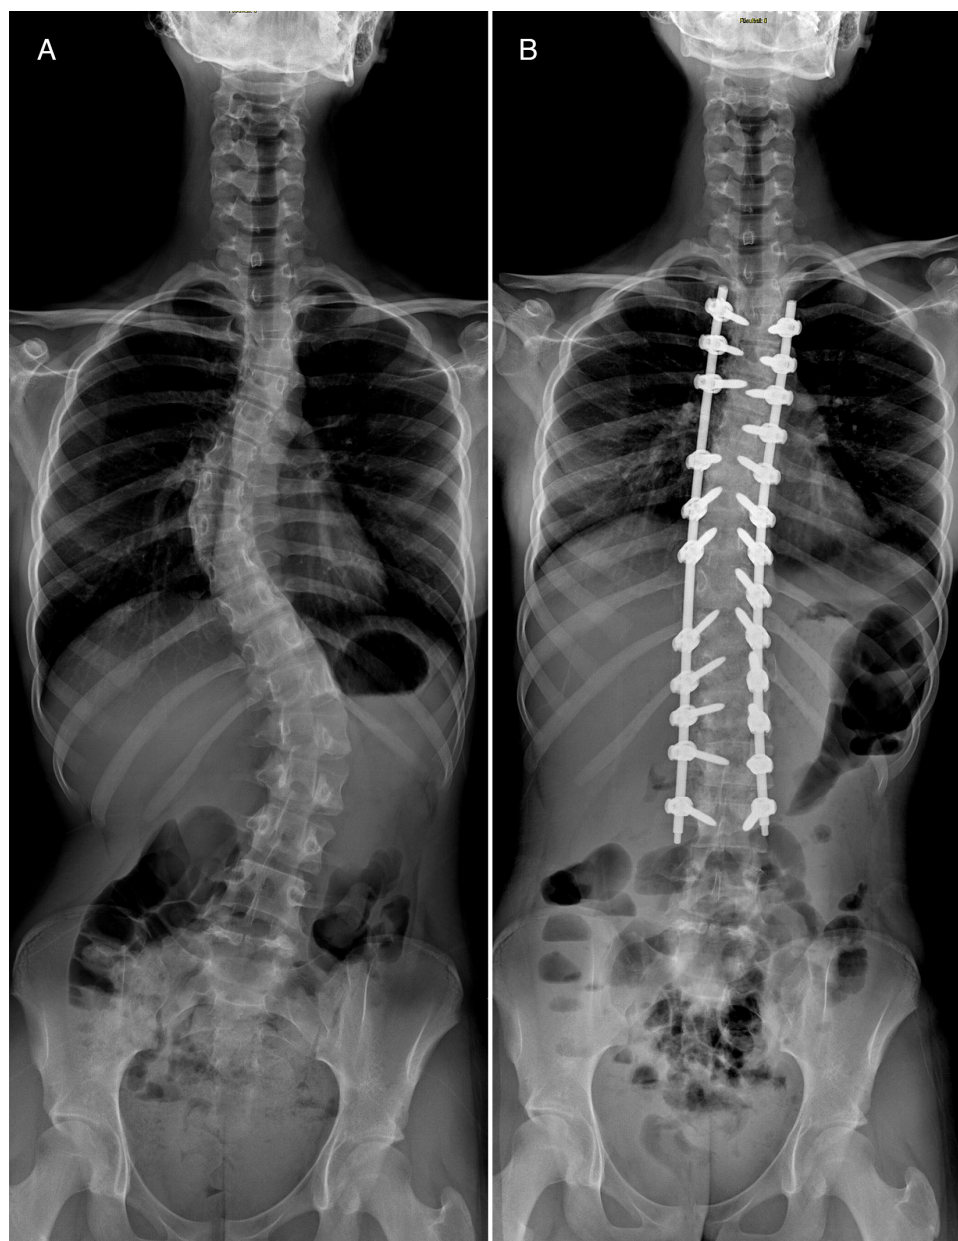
(A) Preoperative and (B) Postoperative X-rays of a case of adolescent idiopathic scoliosis treated with posterior spinal fusion technique.
